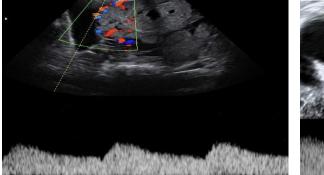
Placental lacunae-transvaginal ultrasound examination
